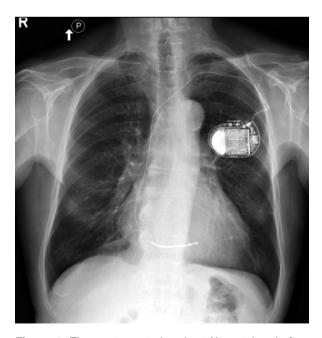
The posteroanterior chest X-ray taken before TLE procedure
